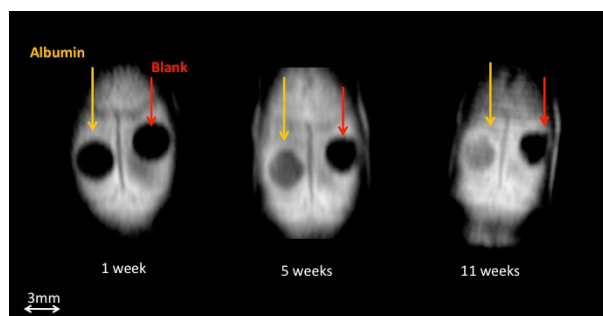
Horizontal reconstructional CT images of bone formation after 1, 5 and 11 weeks. Yellow arrows indicates ossification of albumin coated grafts, red arrows show defects left empty (sham).
